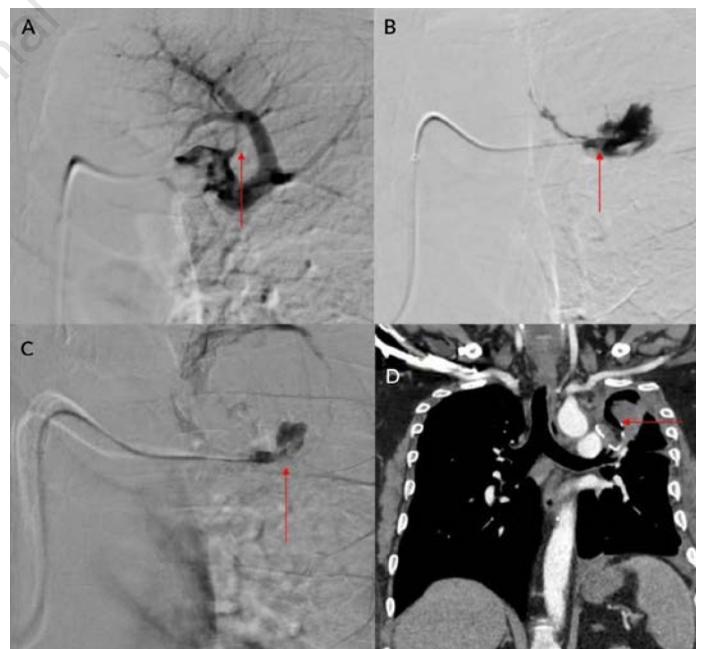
Glue embolization. (A) Left pulmonary artery angiogram showing a slight irregularity involving the apicoposterior segmental branch. (B) Microcatheter injection revealed contrast extravasation into the cavity suggestive of pseudoaneurysm rupture. (C) Glue injection fills the artery and the lining of the cavity. (D) Follow-up contrast-enhanced computed tomography chest after surgical removal of the left upper lobe showing non-filling of the pseudoaneurysm and surgical sutures noted in situ.
